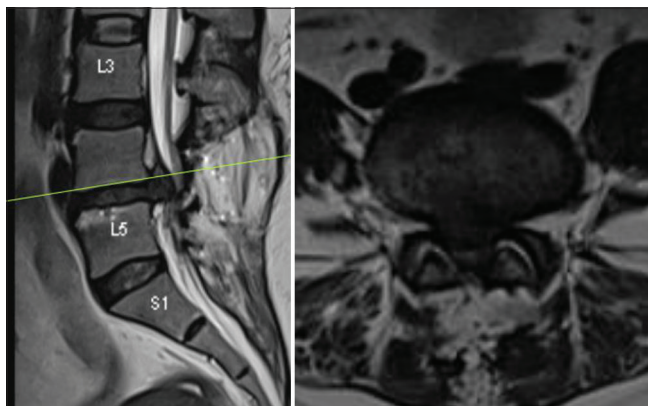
Preoperative sagittal and axial magnetic resonance imaging sections of patient with recurrent L4-L5 disc prolapse of patient 1.
